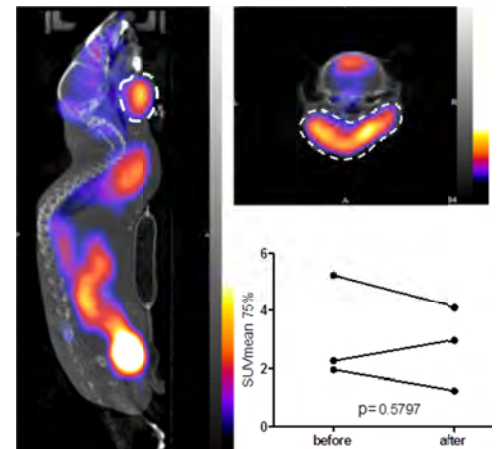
Representative FDG-PET performed before the administration of cyclophosphamide (left and upper right). SUVmean calculated before and after the treatment (lower right).
